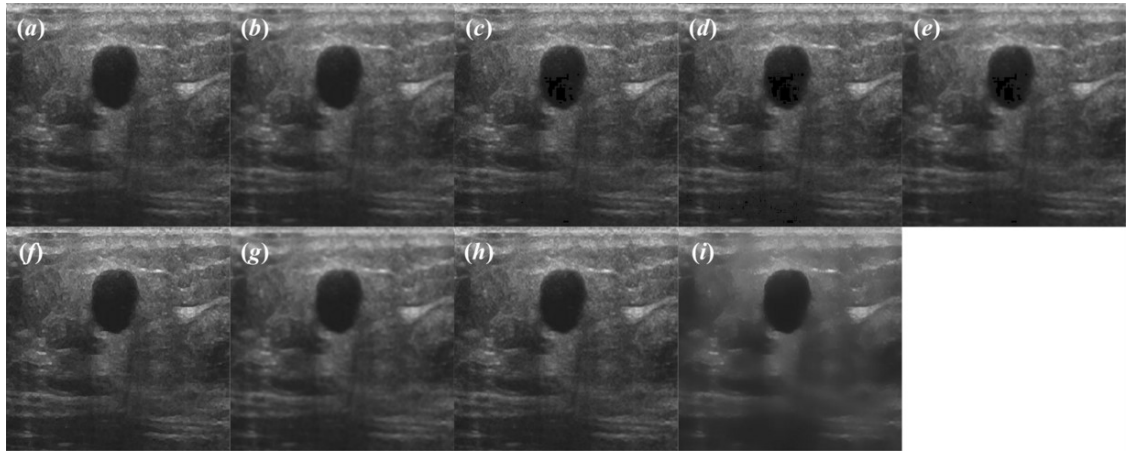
(a) Sample ultrasound image of benign tumor and (b) - (i) corresponding images despeckled by (b) Lee filter, (c) Lee Sigma filter, (d) Kuan filter, (e) Frost filter, (f) Lsminsc filter, (g) Lsmv filter, (h) Wiener filter and (i) FBL filter.
